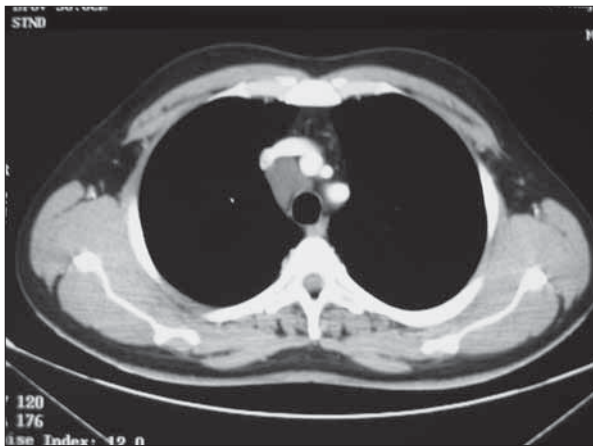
Preoperative chest computed tomography
